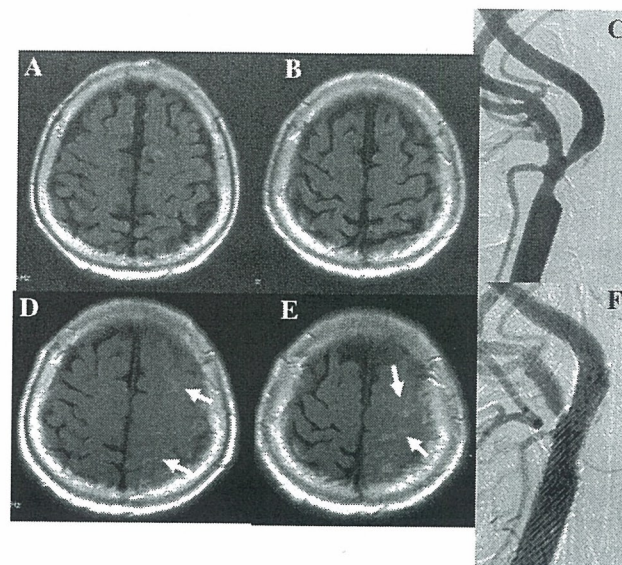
Sample images of the same anatomic slice from a patient who underwent a scheduled stent procedure that showed CSF space enhancement within portions of the left frontal and parietal lobes, ipsilateral to the stented artery A, B FLAIR image before stenting; C conventional angiogram of the carotid bifurcation after stenting; D, E FLAIR image after stenting showing hyperintensity of the CSF space compared with the preoperative FLAIR image (*arrow*); F conventional angiogram of the carotid bifurcation after stenting
